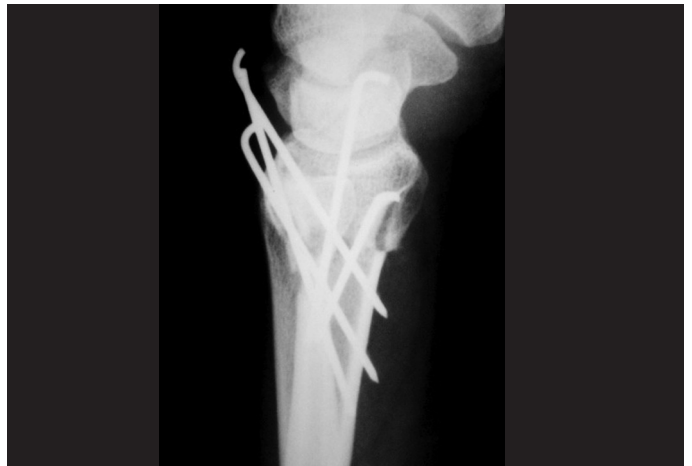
Radiograph on wrist showing the immediate postoperative result in lateral view, with correction of the dorsal deviation of the distal radius.
